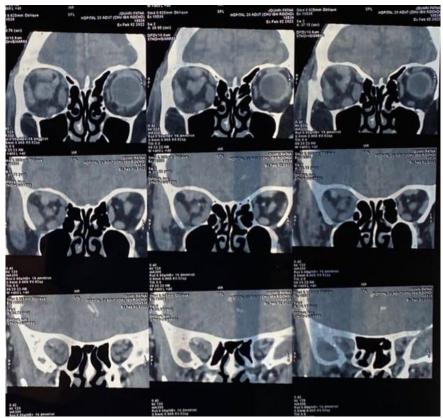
Cerebral and orbital CT revealed a right carotid-cavernous fistula with grade I exophthalmos.
